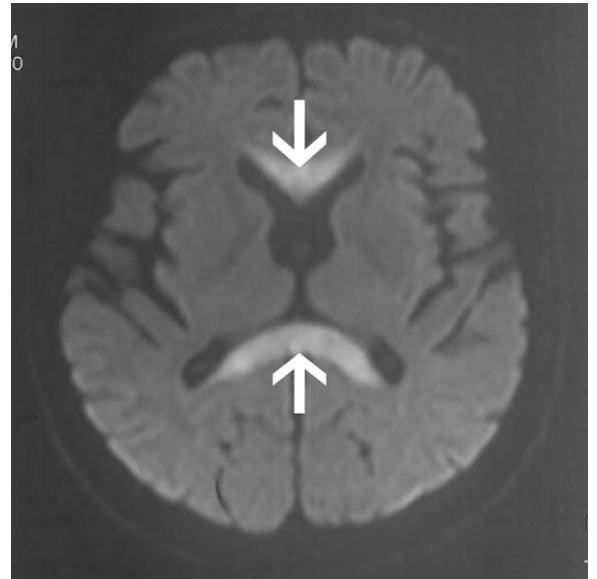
DWI showing abnormal hyperintensity in corpus callosum.
